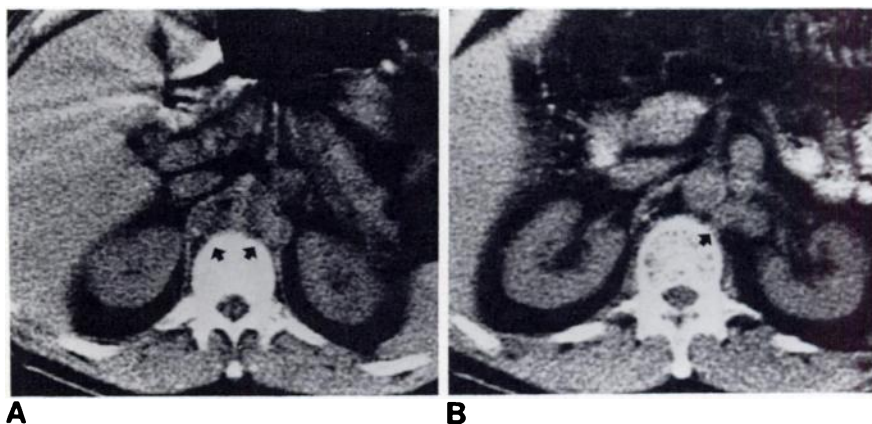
Probable retroperitoneal metastases, but no surgical proof. A, CT through upper abdomen. Bulky adenopathy in retrocrural region (arrows). B, CT through renal hilum. Enlarged nodes (arrow) in left renal area.
